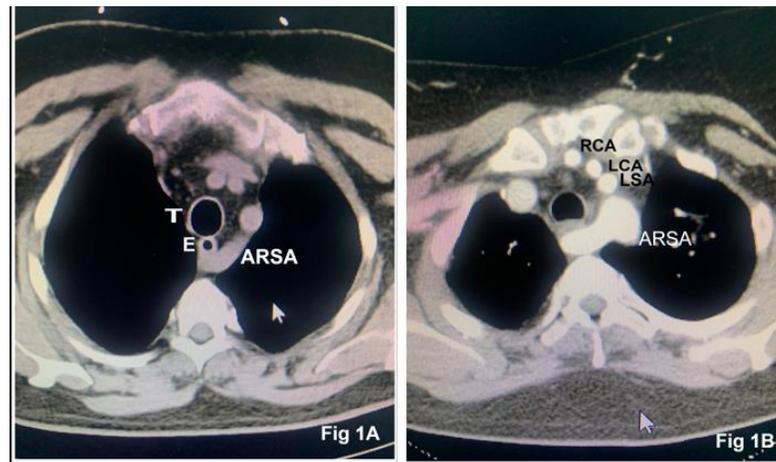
Preoperative computed tomography showing the aberrant right subclavian artery (ARSA) coursing behind the trachea (T) and esophagus (E) (Fig 1A). Axial sections depicting the relationship of ARSA to arch vessels (RCA: right carotid artery, LCA: left carotid artery, LSA: left subclavian artery) and trachea (Fig 1B)
